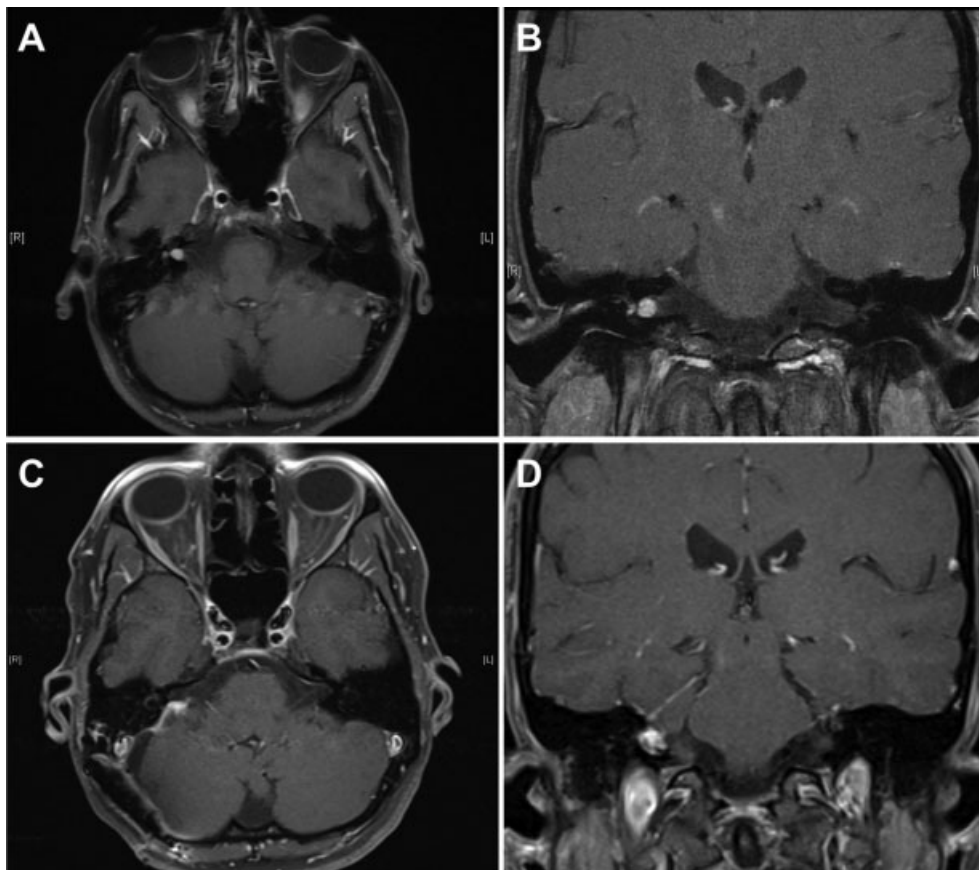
Preoperative brain magnetic resonance imaging (MRI) with gadolinium contrast axial (A) and coronal (B) view showing a right intracanalicular tumor which extended far laterally to the fundus. At 6 weeks of follow-up, postoperative axial (C) and coronal (D) brain MRI with gadolinium contrast demonstrating complete resection of the lesion and scarring of the internal auditory canal.
